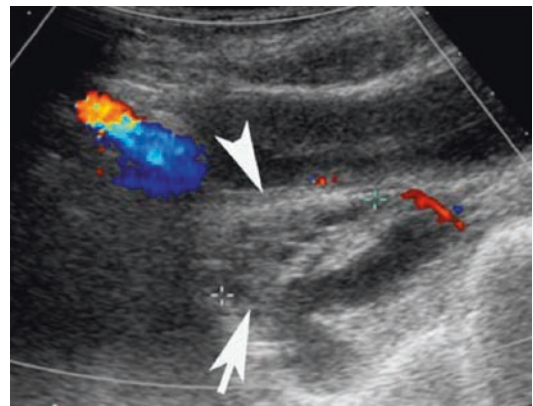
US appearance of a torsed tube: US images show a complex structure next to the right ovary, with no flow apparent on the Doppler image
